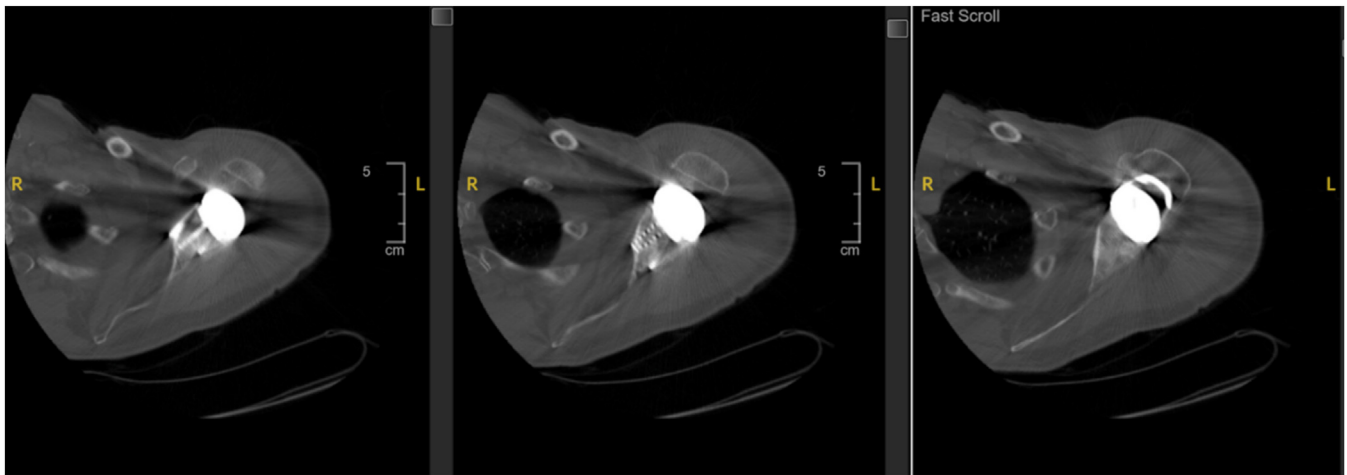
Axial CT images showing complete incorporation of humeral head autograft 4 years after index operation. No fractures, lucencies or migration present despite traumatic event. CT, computed tomography.
